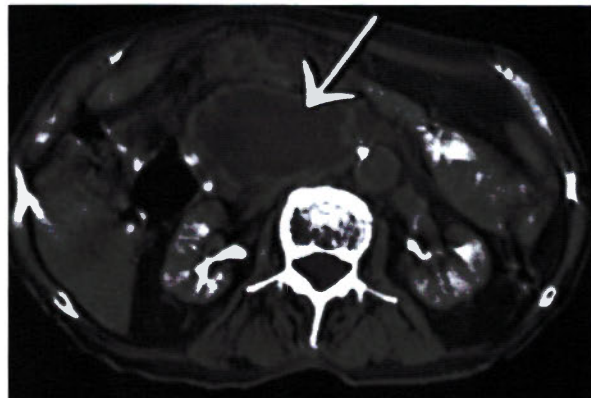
CT Showing Pancreatic Pseudocyst
